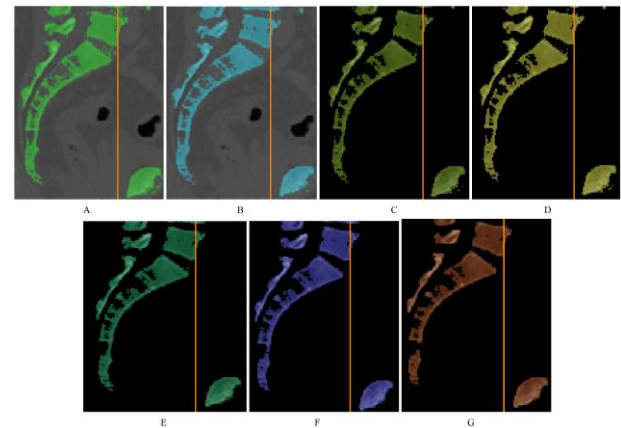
Close-up view of CT slice filtering results: (A) original, (B) thresholded (130-1500), (C) mean 3×3 , (D) median 3×3 , (E) median 5×5 , (F) median 7×7 , (G) median 9×9
